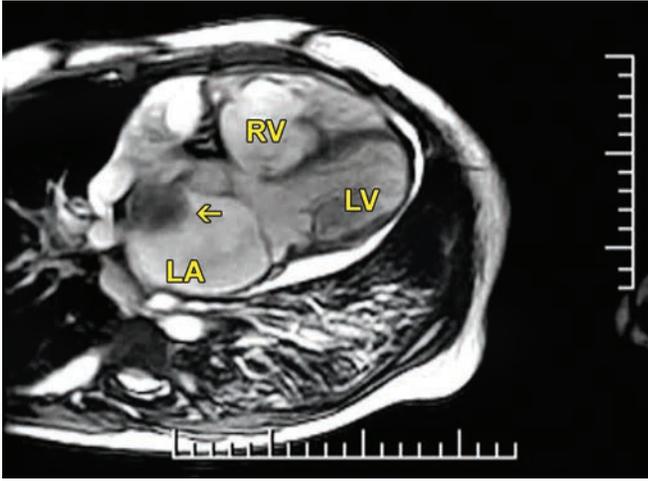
Magnetic resonance imaging (MRI). Arrow shows a large mass in the left atrium.
